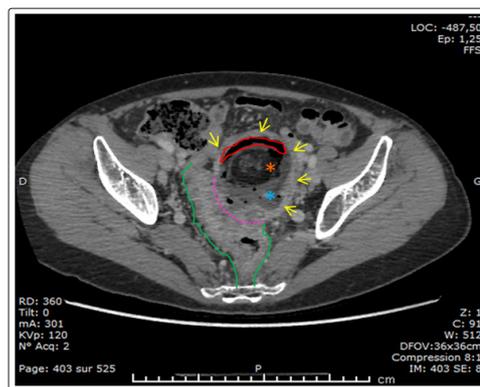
Axial section of an injected pelvic CT-scan showing thickened and infiltrated sigmoid walls (green lines), with a zone of continuity with a left ovarian cyst about 6 cm (pink dotted line). The left ovarian cyst, 8 cm in diameter, presents thickened walls (yellow arrows) and heterogeneous contents in favor of a dermoid-cyst : fat and sebum (orange asterisk), upper aeric level (red line) and liquid with air bubbles (blue asterisk) suspicious of a fistula with intra-cystic abscess.
